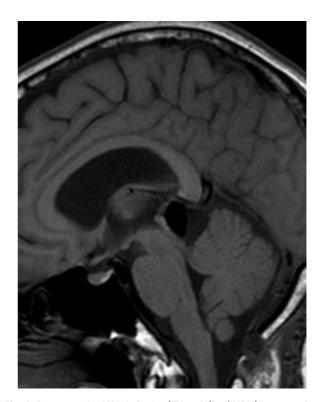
Postoperative MRI. A: Sagittal T1-weighted MRI demonstrating gross total resection.
